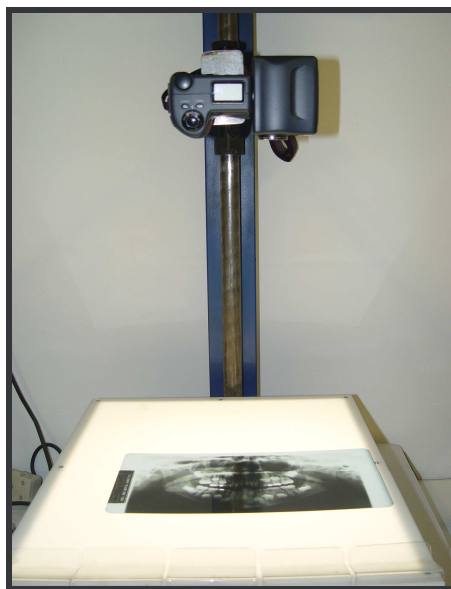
Mounted camera and radiograph on the viewing box
